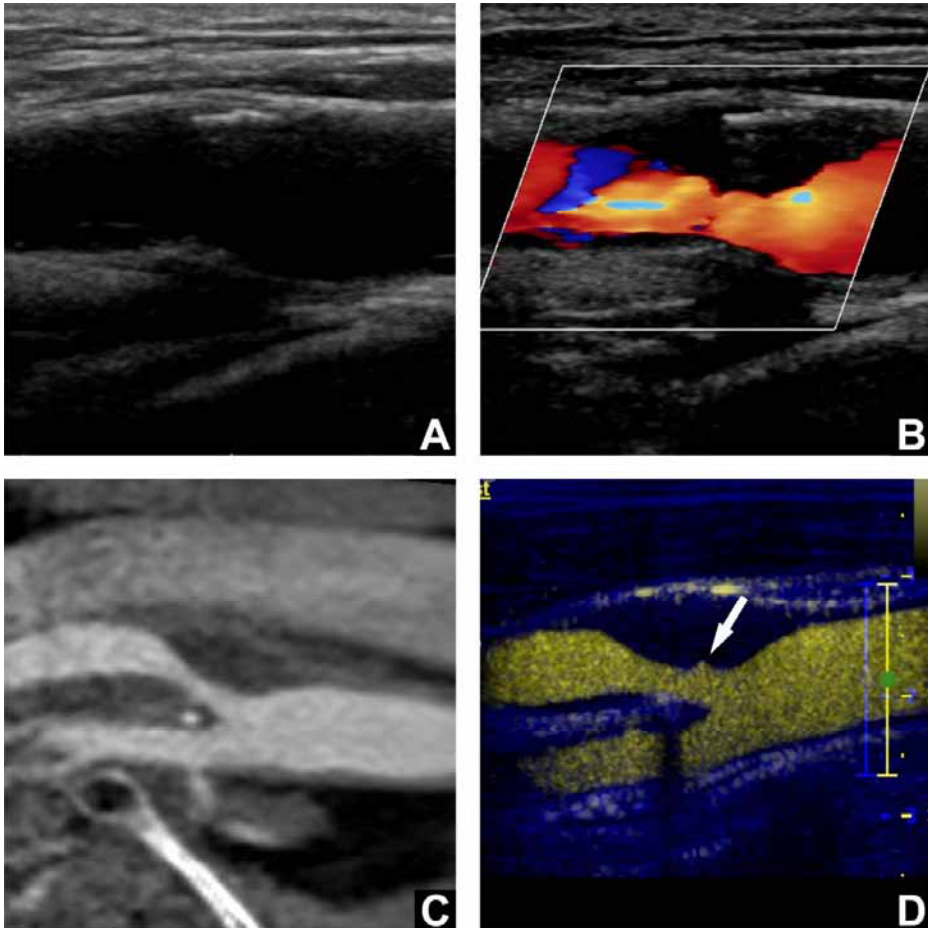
Longitudinal images of carotid plaque classified as ulcerated with CEUS and smooth with CTA. Longitudinal B-mode ultrasound (A), CDUS (B), CTA (C), and CEUS (D). A hypoechoic plaque was present in the near wall of the carotid artery, the full extent of which was not visible on B-mode ultrasound (A). CDUS (B) provided improved visualization of the plaque size but did not identify an ulcer. (D) CEUS demonstrated a small ($\sim 1 \times 2$ mm) ulcer (arrow) not visible using CDUS or CTA (C).
